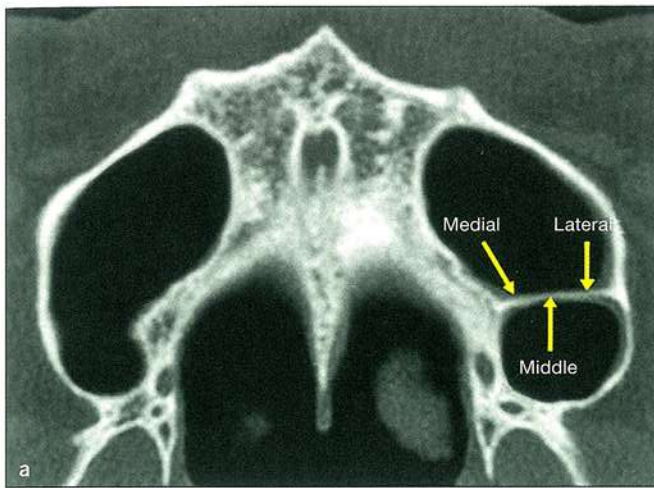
(a) CBCT axial view demonstrating maxillary sinus septa. (b) 3D CBCT rendering demonstrating maxillary sinus septa.
